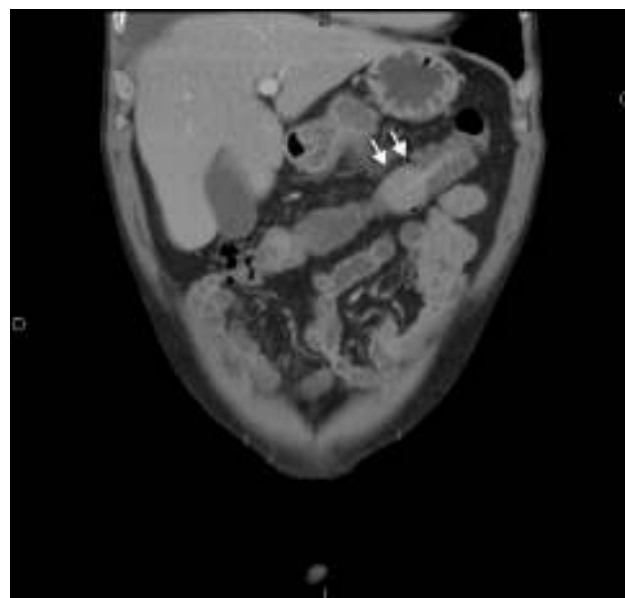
Computed tomography (coronal slice). The polyp causing the intussusception can be seen (→).
